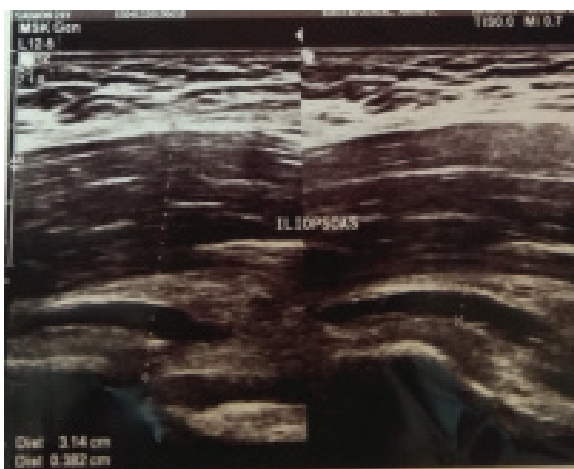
Ultrasonogram showing iliopsoas haematoma
